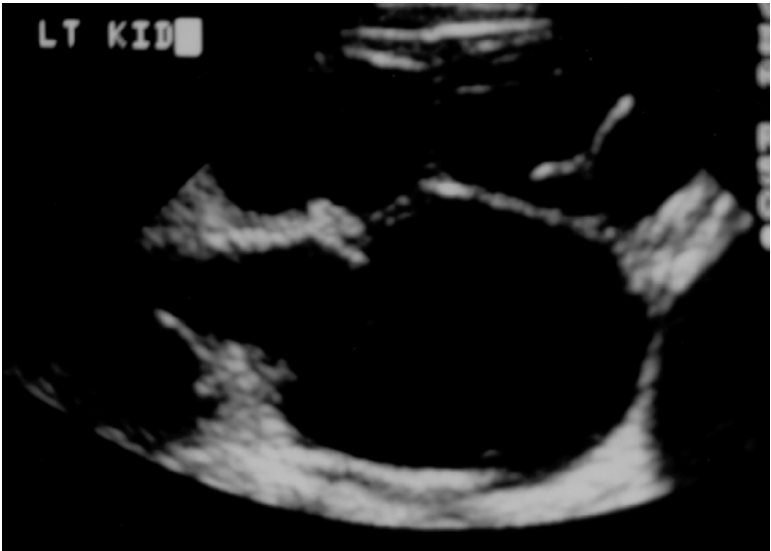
Severely hydronephrotic left kidney, with thin parenchyma. At the bottom right of the ultrasound is the bladder.
